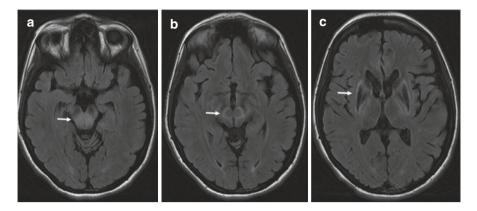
MRI of the brain 8 months after chelation therapy was initiated. She was started on D-penicillamine at an outside institution, and within 1 month she developed severe dystonia with mutism and severe Parkinsonism. This was irreversible and her neurologic deficits were fixed. Flair imaging showed worsening of hyperintensity in the midbrain (panel a) with the appearance suggestive of face of the giant panda (panel b). Severe cystic changes were detected in basal ganglia (panel c)
